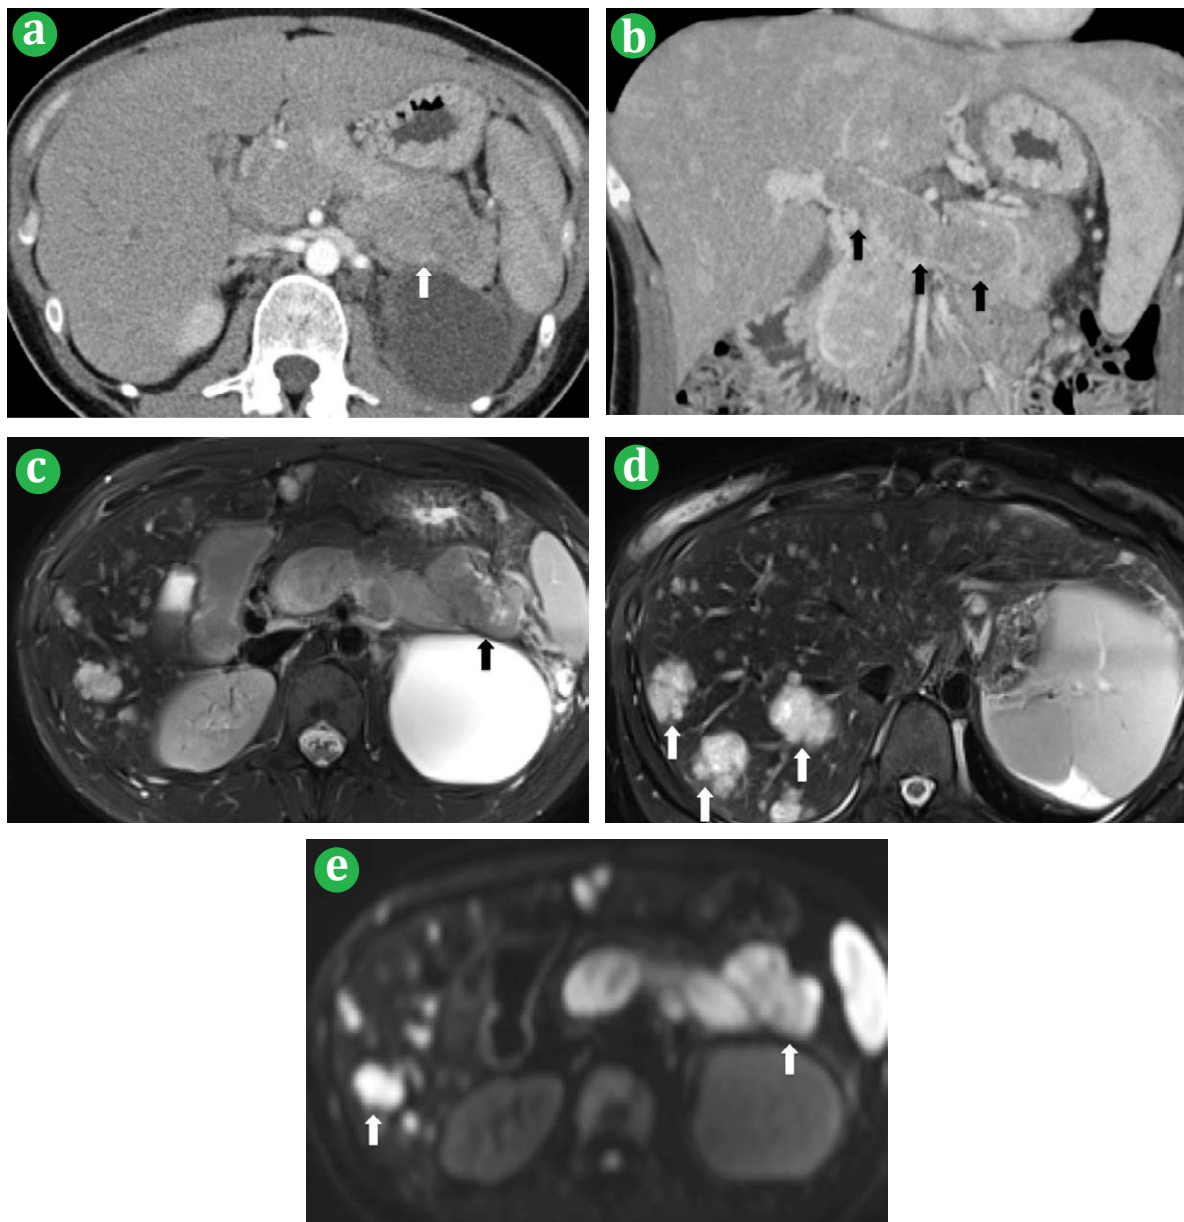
Hypo-enhancing tumor (Non-functional tumor). (a). Computed tomography images during the arterial phase show a hypovascularized tumor of the pancreas as shown in pancreatic adenocarcinoma. The lesion has a worse prognosis compared with hyperechoic or cystic and hyper-enhancing tumors. (b). Computed tomography images during the portal venous phase show a tumor thrombus in the portal vein. (c). Magnetic Resonance images: A T2-weighted image shows a heterogenous hyperintense tumor. (d). Magnetic Resonance images: A T2-weighted image shows multiple liver metastases better depicted than on computed tomography scan. (e). The pancreatic tumor and liver metastases are also well depicted on diffusion weighted images.
